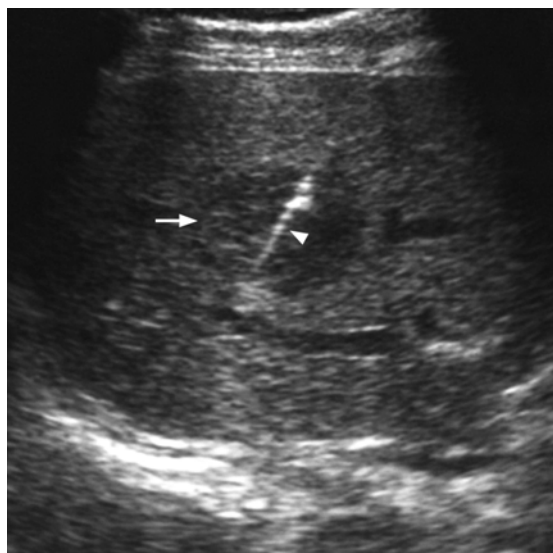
Ultrasound scan showing a small HCC of homogeneous and hypoechoic echotexture (arrow), which may not be distinguishable from the echopattern of regeneration nodules in cirrhosis.
